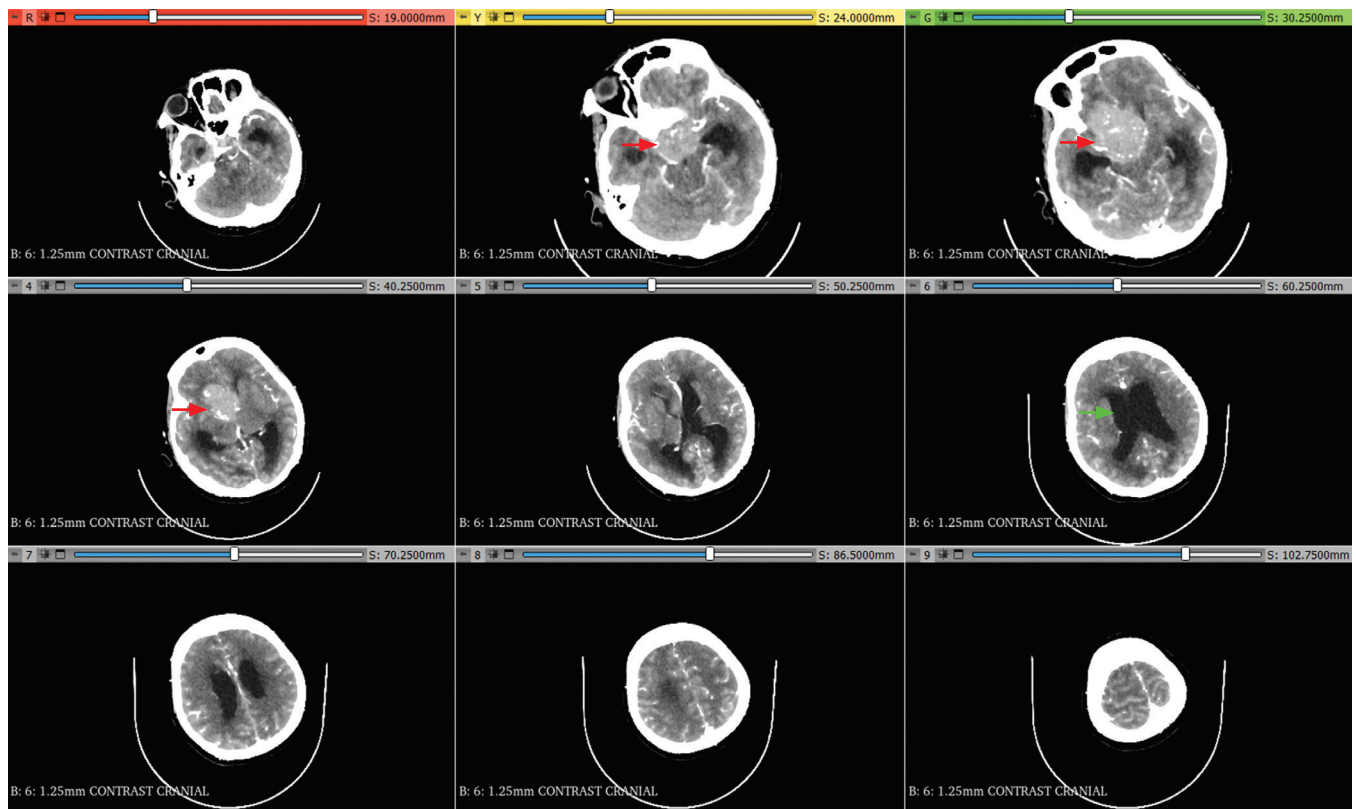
Axial view cranial CT scan with contrast. Sellar-suprasellar mass marked by red arrows. Dilated lateral ventricles due to compression of the 4th ventricle and cerebral aqueduct marked by green arrow.
